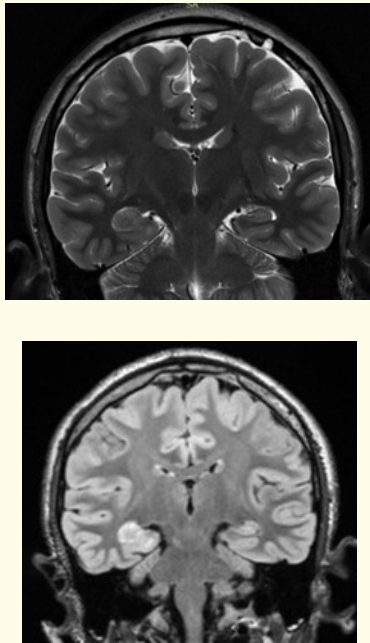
High resolution 3T MRI T1W (A), T2W (B), T2 FLAIR (C) images showing right hippocampus and parahippocampal gyrus altered signal intensity suggestive of a low grade glioneuronal lesion.
